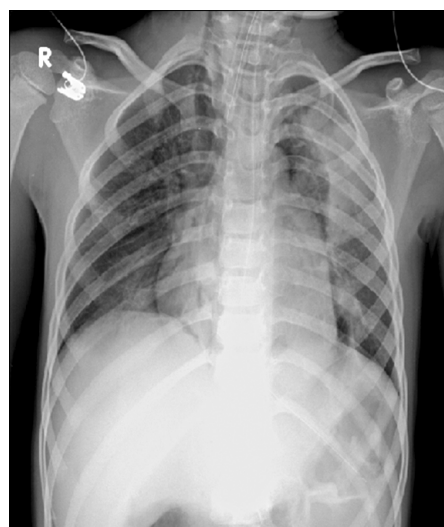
Chest X-ray obtained immediately after weaning of extracorporeal membrane oxygenation. The outflow catheter was removed, and consolidation of the left upper lung zone was mildly improved. R, right.
